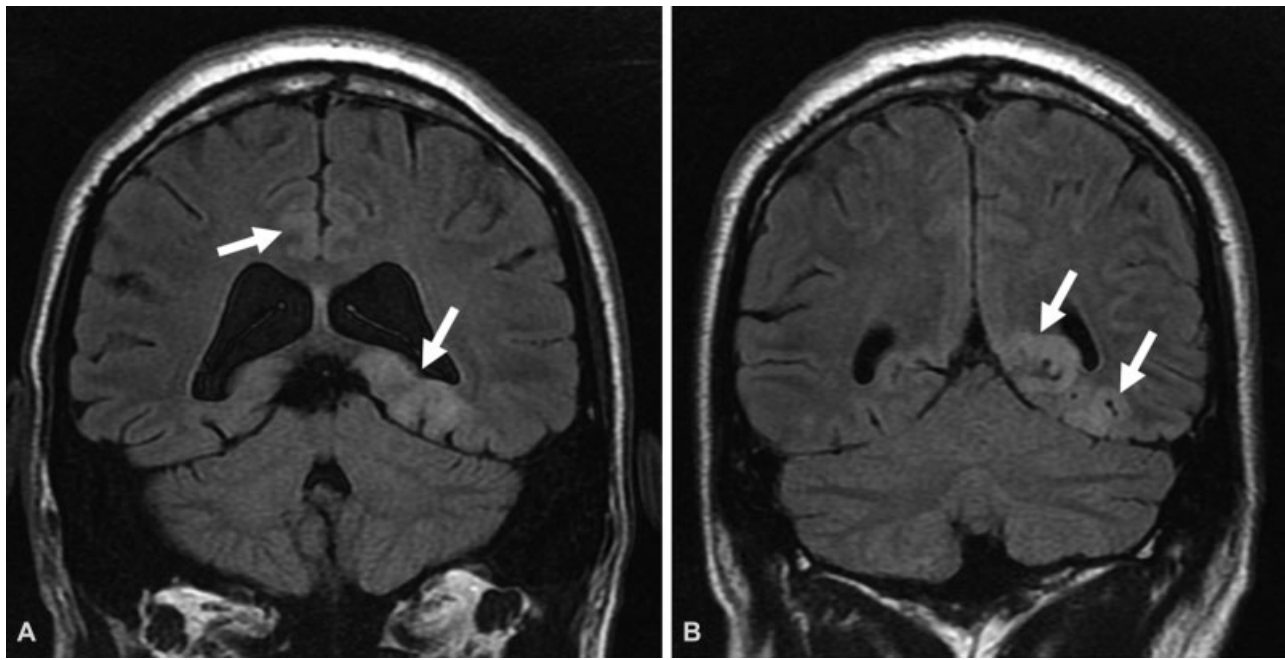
(A) Coronal FLAIR sequence showing hyperintense signal in the left medial temporal lobe and the right medial parietal cortex (arrows). (B) Coronal FLAIR sequence showing hyperintense signal in the left medial parietal-occipital lobes (arrows). FLAIR, fluid-attenuated inversion recovery.
